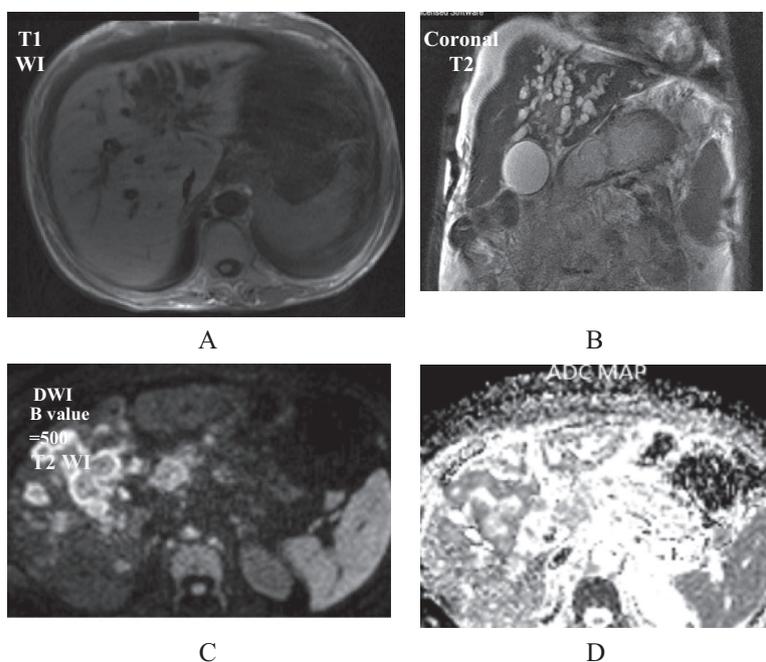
(A–D) Male patient aged 55 years presented with obstructive jaundice. MRI findings: A tumor mass centralized upon the common hepatic and left hepatic ducts and associated with bi-lobar biliary obstruction. The mass exhibits hypointense SI on both T1WI and T2WI, heterogeneous high signal intensity on diffusion study and low SI in the ADC map with mean ADC value = 1.2×10^{-3} s/mm². The lesion showed typical imaging findings of cholangiocarcinoma.
